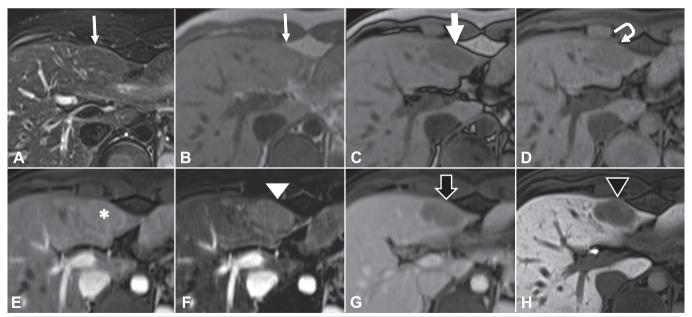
Suspected hepatic adenoma. MRI showing usual imaging features of HNF-1α-mutated adenoma. Signal intensity on T1- and T2-weighted images varies according the amount of fat inside. This nodule have signal intensity similar to liver (thin arrow) on T1-weighted (A) and T2-weighted (B) images. There is a signal drop (thick arrow) of the lesion on out-of-phase image (C) related to fat and a loss of signal (curved arrow) on fat-suppressed pre-contrast phase (D). On dynamic contrast images, the intensity of enhancement (asterisk) on arterial phase (E) is related to the amount of fat, better seen (arrowhead) in this case on subtracted image (F). There are hypointensity (open arrow) on portal-venous phase (G) representing washout and reduced contrast uptake (open arrowhead) on hepatobiliary phase (H).
